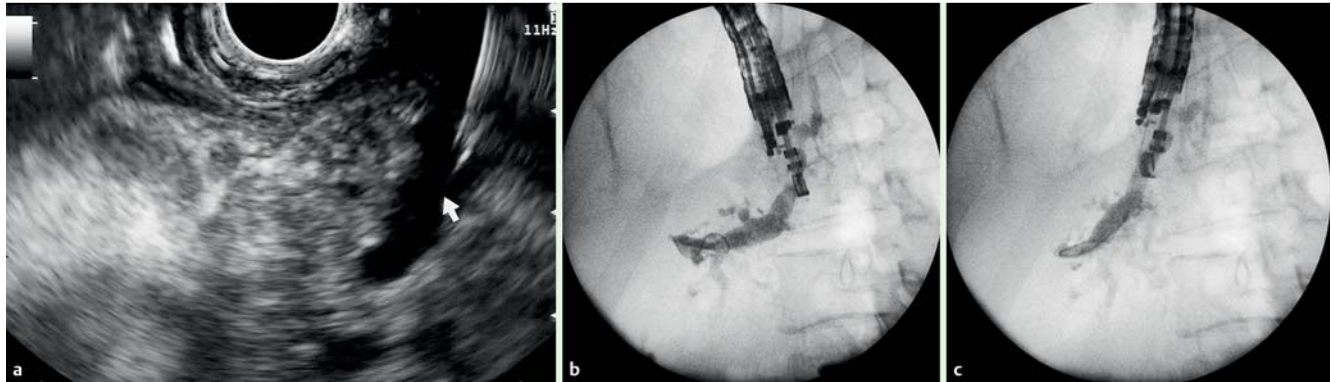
Endoscopic ultrasound (EUS)-guided access to the pancreatic duct. a Transgastric puncture of the dilated pancreatic duct using a 19-gauge needle (Expect Flex; Boston Scientific, Marlborough, Massachusetts, USA). b EUS-guided pancreatography revealed a dilated, tortuous main pancreatic duct, and severe stricture in the cephalic pancreatic area. A 0.035-inch guidewire was advanced through the pancreatic duct. c Fluoroscopic view of the 6 Fr cystostome over the guidewire.
